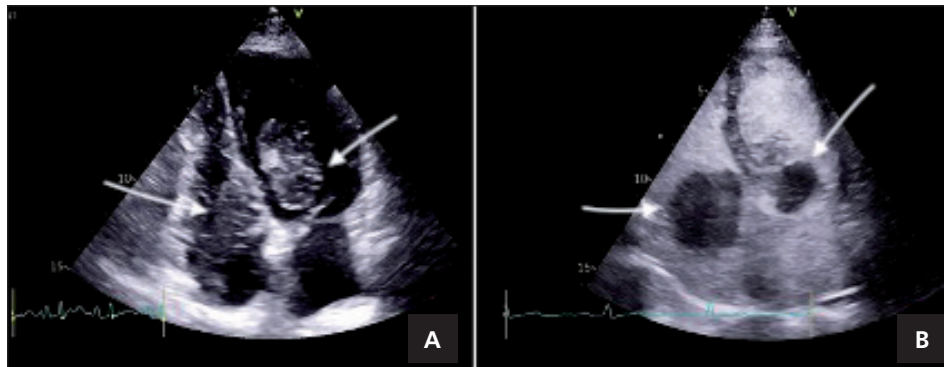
Transthoracic echocardiography revealed two cardiac masses (white arrows): right atrium (32×38 mm) and left ventricle (42×32 mm), both with mobility and causing dynamic obstruction of the tricuspid valve and left ventricular outflow tract (A). Contrast echocardiography revealed hyper-enhancement of these masses with contrast (B, white arrows).
